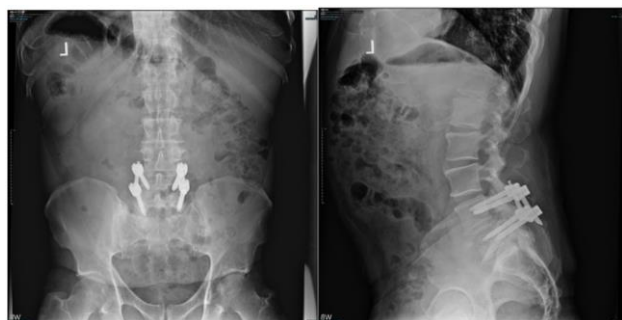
Post-revision X-rays dated 7/9/21 showing two views of the lumbar spine. Images show L4-L5 fusion with no signs of complication. Vertebral bodies of L4 and L5 show no signs of gross infection. No gas or fluid levels are appreciated in the soft tissue. Images show the removal of spacer as intended from the intervertebral space.
